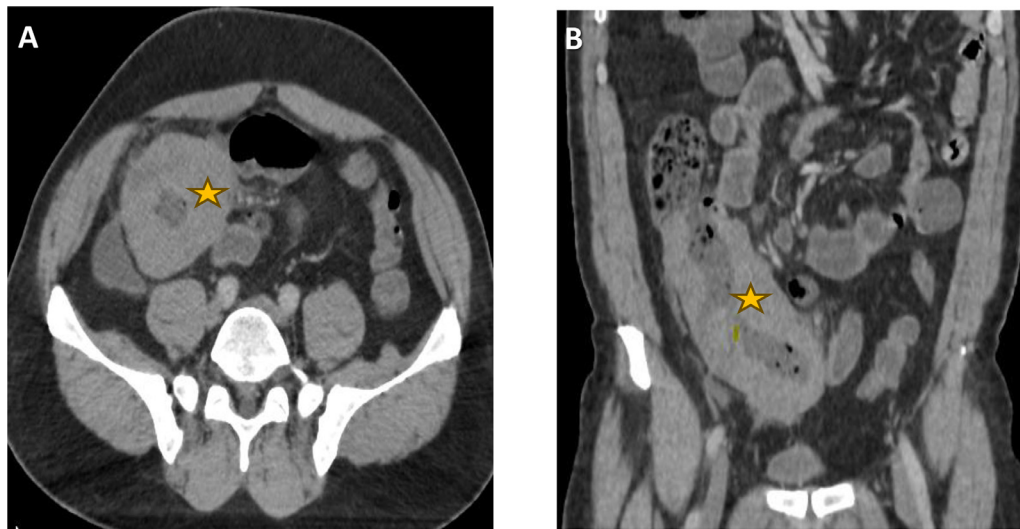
Abdominal CT with PDC injection in axial (A) and coronal (B) sections showing pseudo-stenotic ileo-caecal parietal circumferential tumour thickening (orange star) with discrete infiltration of adjacent fat.
